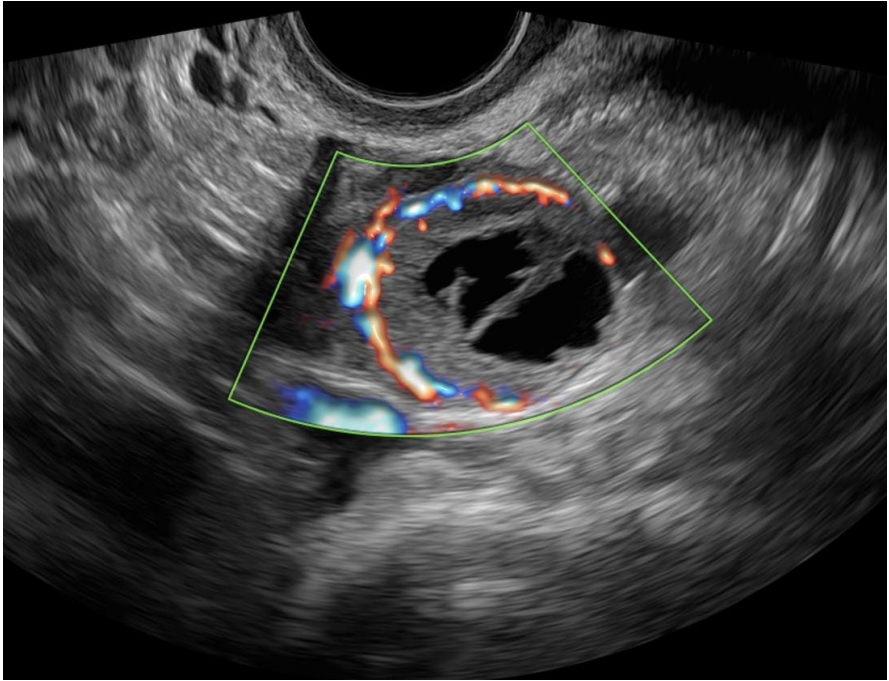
Colour Doppler showing circumferential flow of a right corpus luteum representing neo-agenesis in a pre-menopausal woman.
